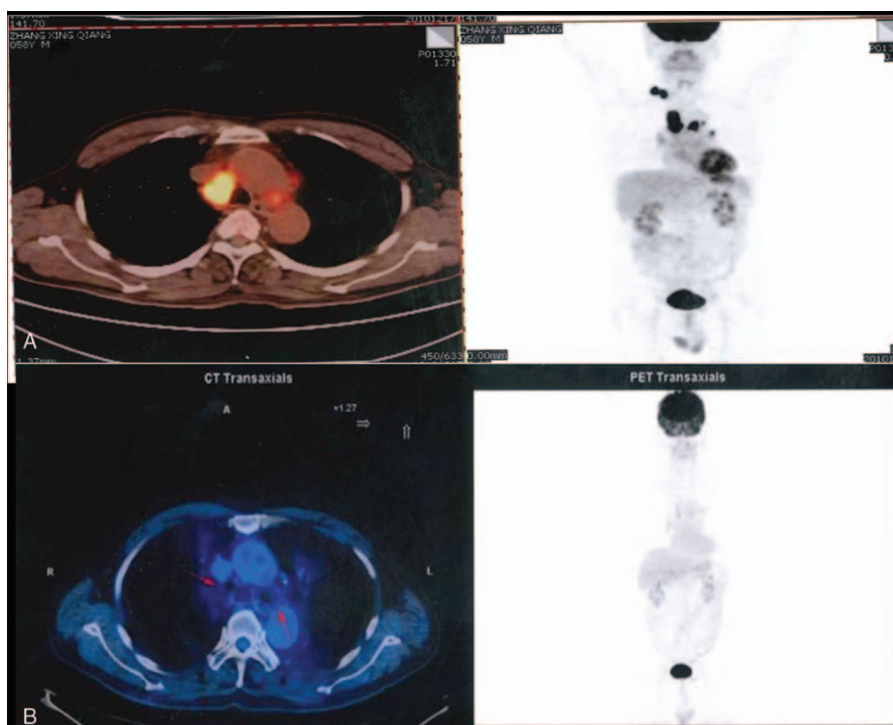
Images of PET-CT scans. A, Prior to the combination treatment. B, After the combination treatment, the patient was disease free. PET-CT = positron emission tomography-computed tomography.
